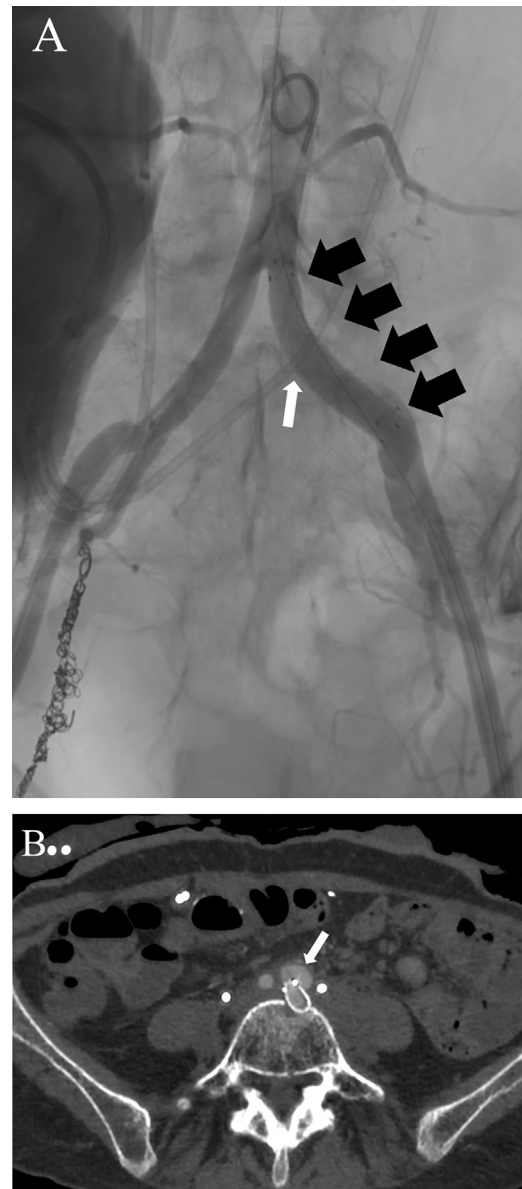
(A) An 8 × 50 mm Viabahn stent-graft (black arrows) was placed so that the left common iliac artery could seal the ureteroarterial fistula (white arrow). The patient had a history of embolization of the right inferior gluteal artery due to pelvic bleeding. (B) Contrast-enhanced computed tomography (CECT) image obtained 8 months after the placement of a stent-graft revealed a pseudoaneurysm (white arrow) with periarterial soft tissue thickening at the proximal edge side of the stent-graft, which was at the origin of the left common iliac artery.
